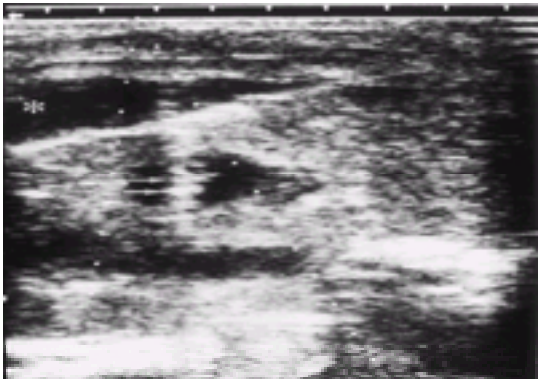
Abdominal ultrasonography reveals a liver abscess with concomitant subphrenic abscess (*). A drainage catheter (arrows) was inserted for abscess drainage.
